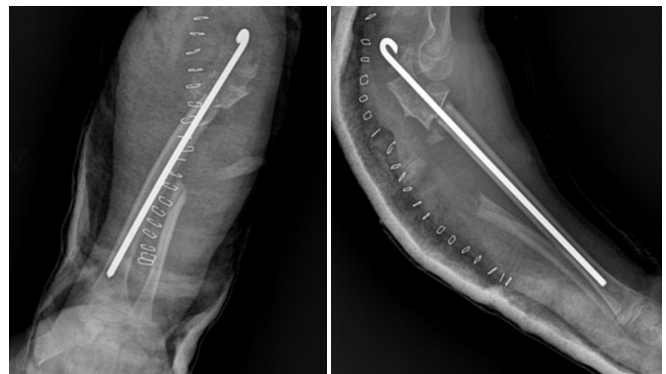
Immediate post-operative radiographs showing single bone forearm fixed with rush nail
